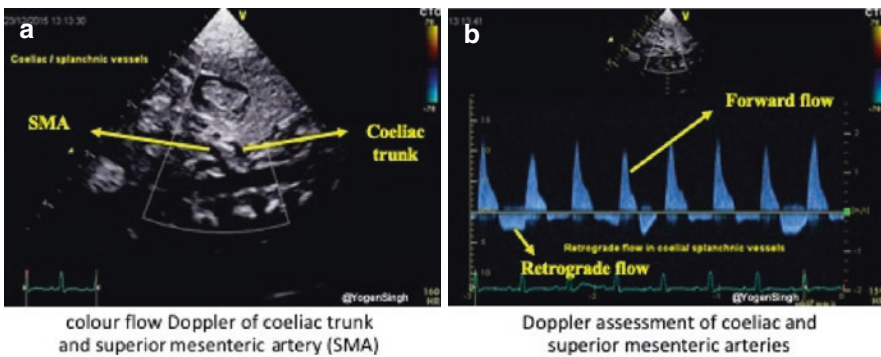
Color flow mapping and pulsed wave Doppler assessment of blood flow in the coeliac trunk and superior mesenteric artery in sub-costal sagittal view. (a) Color flow mapping of the coeliac and superior mesenteric
